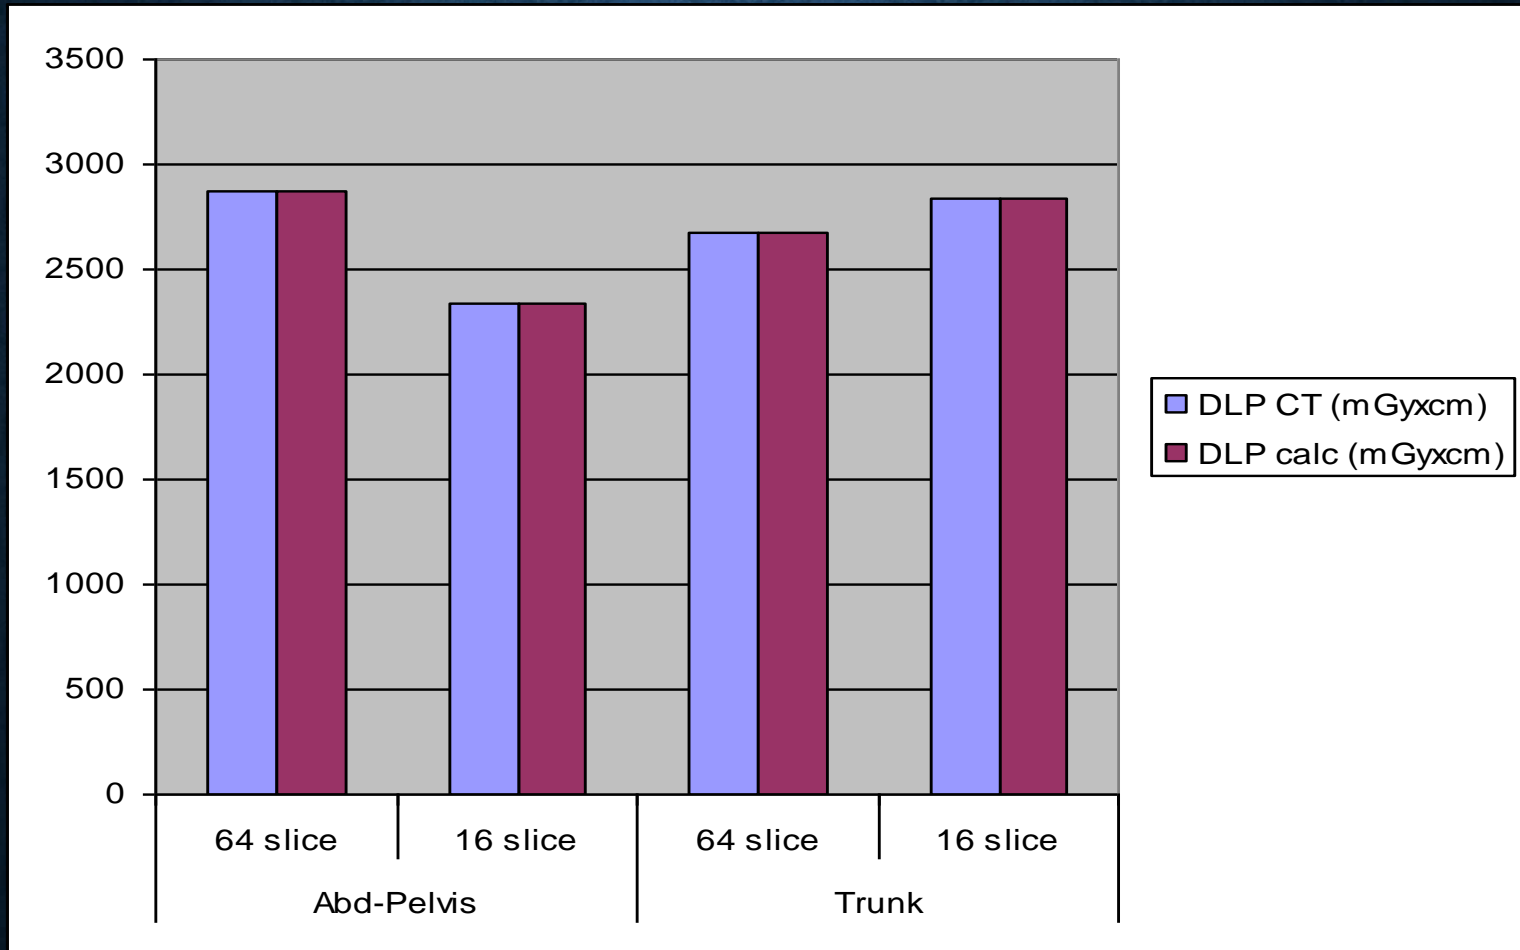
Average DLP (mGy x cm) for 64 slice and 16 slice CT equipment for AP and CAP procedures
